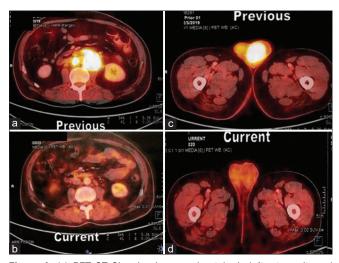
(a) PET CT Showing Increased uptake in left retroperitoneal lymph nodes. (b) Follow up PET CT Showing complete resolution of metabolic activity in previously seen lymph nodes. (c) PET CT Showing increased metabolic activity in left testis and hydrocele. (d) Follow-up PET CT Showing complete resolution of metabolic activity and hydrocele
